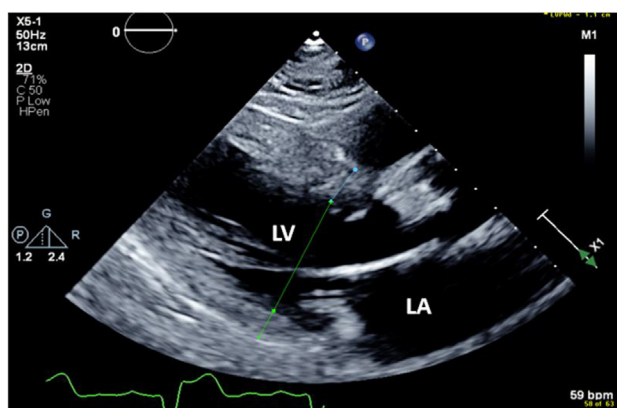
Case 2 two-dimensional TTE, parasternal long-axis end-diastolic view, demonstrates asymmetric left ventricular hypertrophy with septal wall thickness of 1.4 cm and posterior wall thickness of 1.1 cm). LA, Left atrium; LV, left ventricle; RV, right ventricle.
